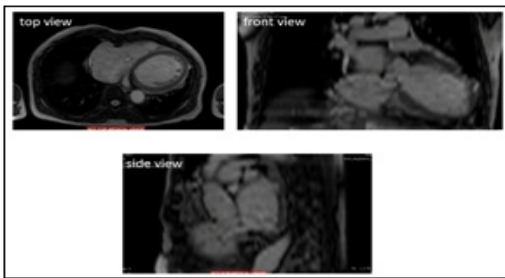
MRI slices from Hospital UITM.
